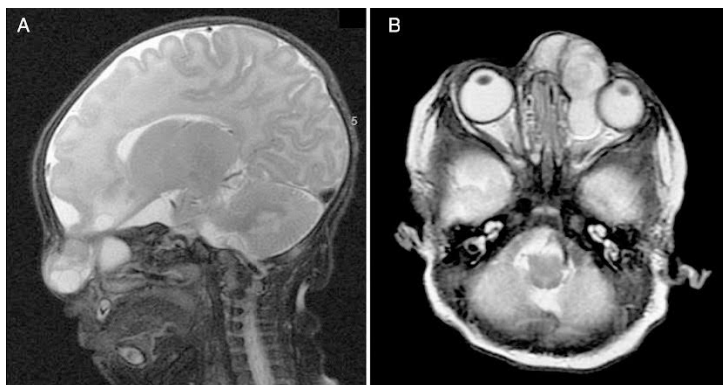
Sagittal (A) and axial (B) magnetic resonance imaging of a nasal encephalocele in a neonate. Image from: Van Heukelom JG. Case 3: an abnormal nose mass. *Neoreviews*. 2019;20(3):e158–e160⁶
